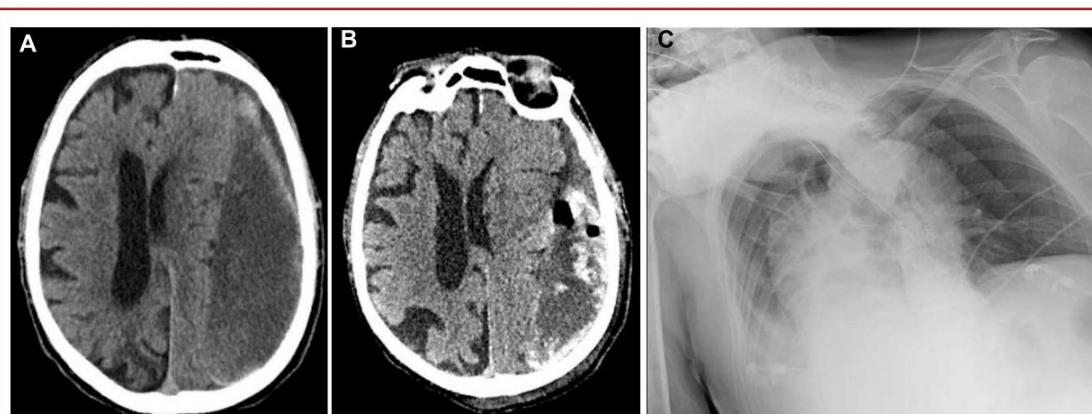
A. Head CT scan, axial view: preoperative left CSDH. B. Head CT scan, axial view: postoperative CSDH with signs of recent rebleeding. C. CXR showing bilateral IP.
